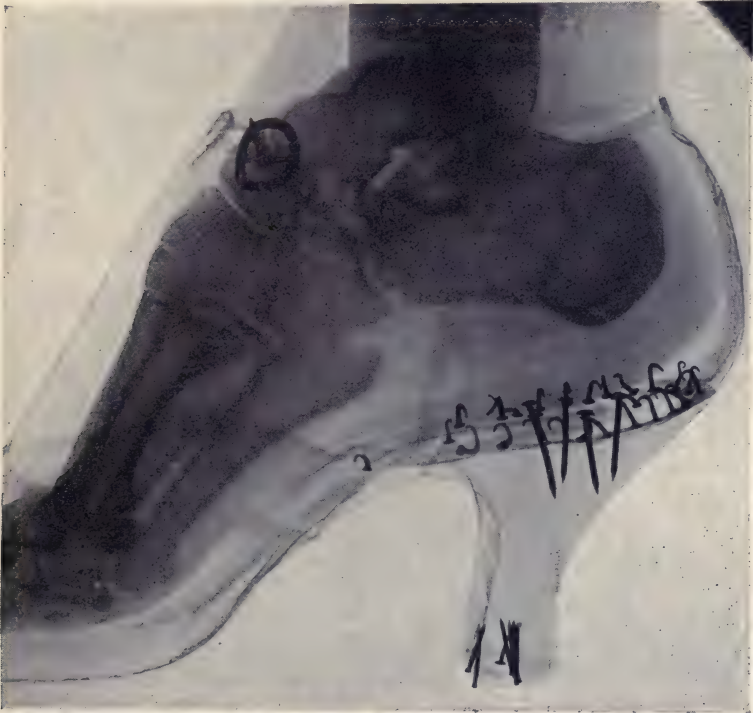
X-ray photograph of the same foot as in fig. 34, but in a high-heeled shoe. The *os calcis* is now nearly parallel with the ground, the long bones of the foot form a sharp angle with the toes and the weight of the body is differently distributed, as compared with the position in fig. 34. Less weight will be borne by the heel, and more by the joint and ligament of the foot.
